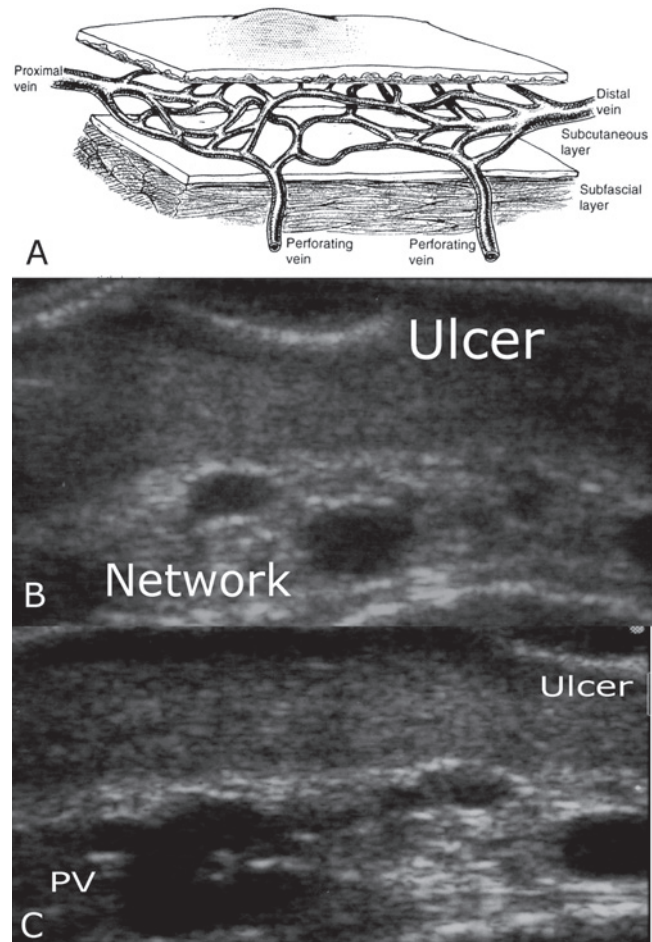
Ultrasound sonography has confirmed the presence of a tangled network of varicose veins of small caliber, reticular varices, and incompetent perforating veins under lipodermatosclerotic plaques and under venous ulcers. These are the targets for successful foam sclerotherapy.
